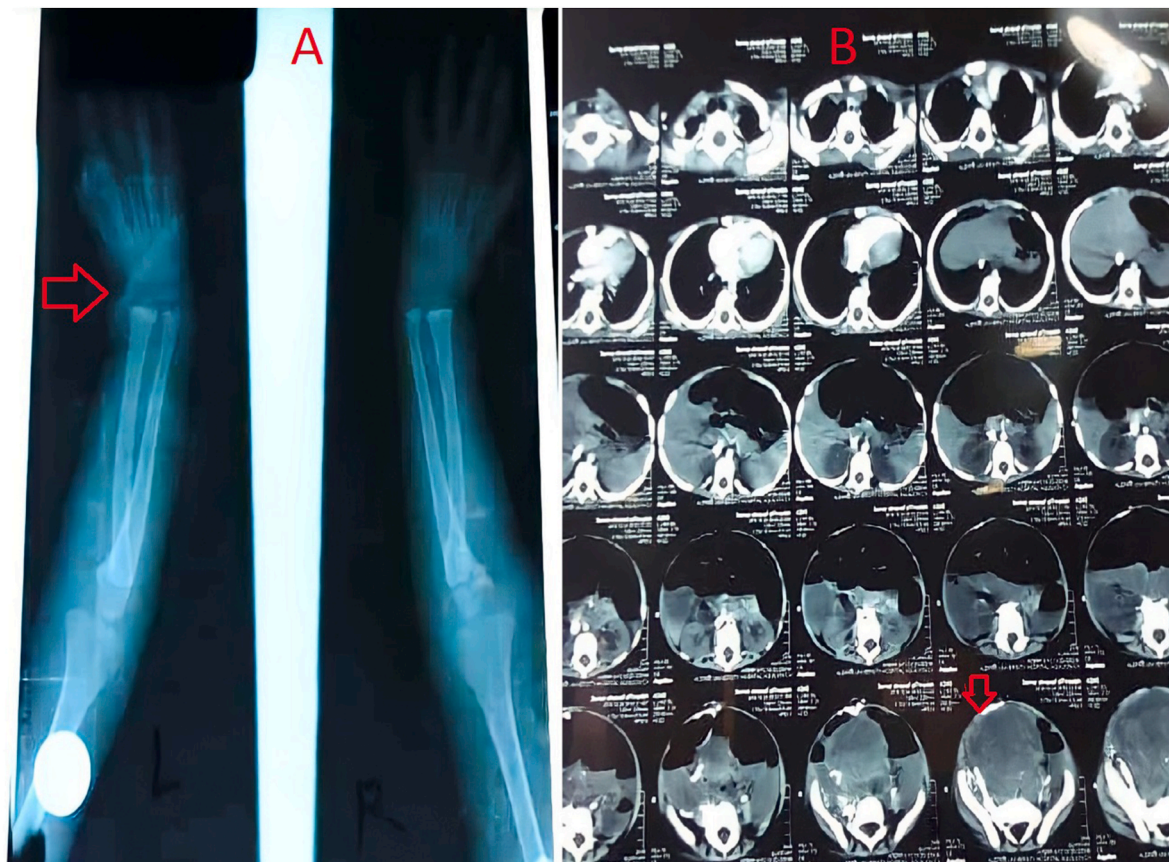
(A) X-ray image reveals delayed ossification of the carpal bones (Arrow). (B) Axial CT image reveals a necrotic mass in the hypogastric region measuring (10–12) cm (Arrow).
